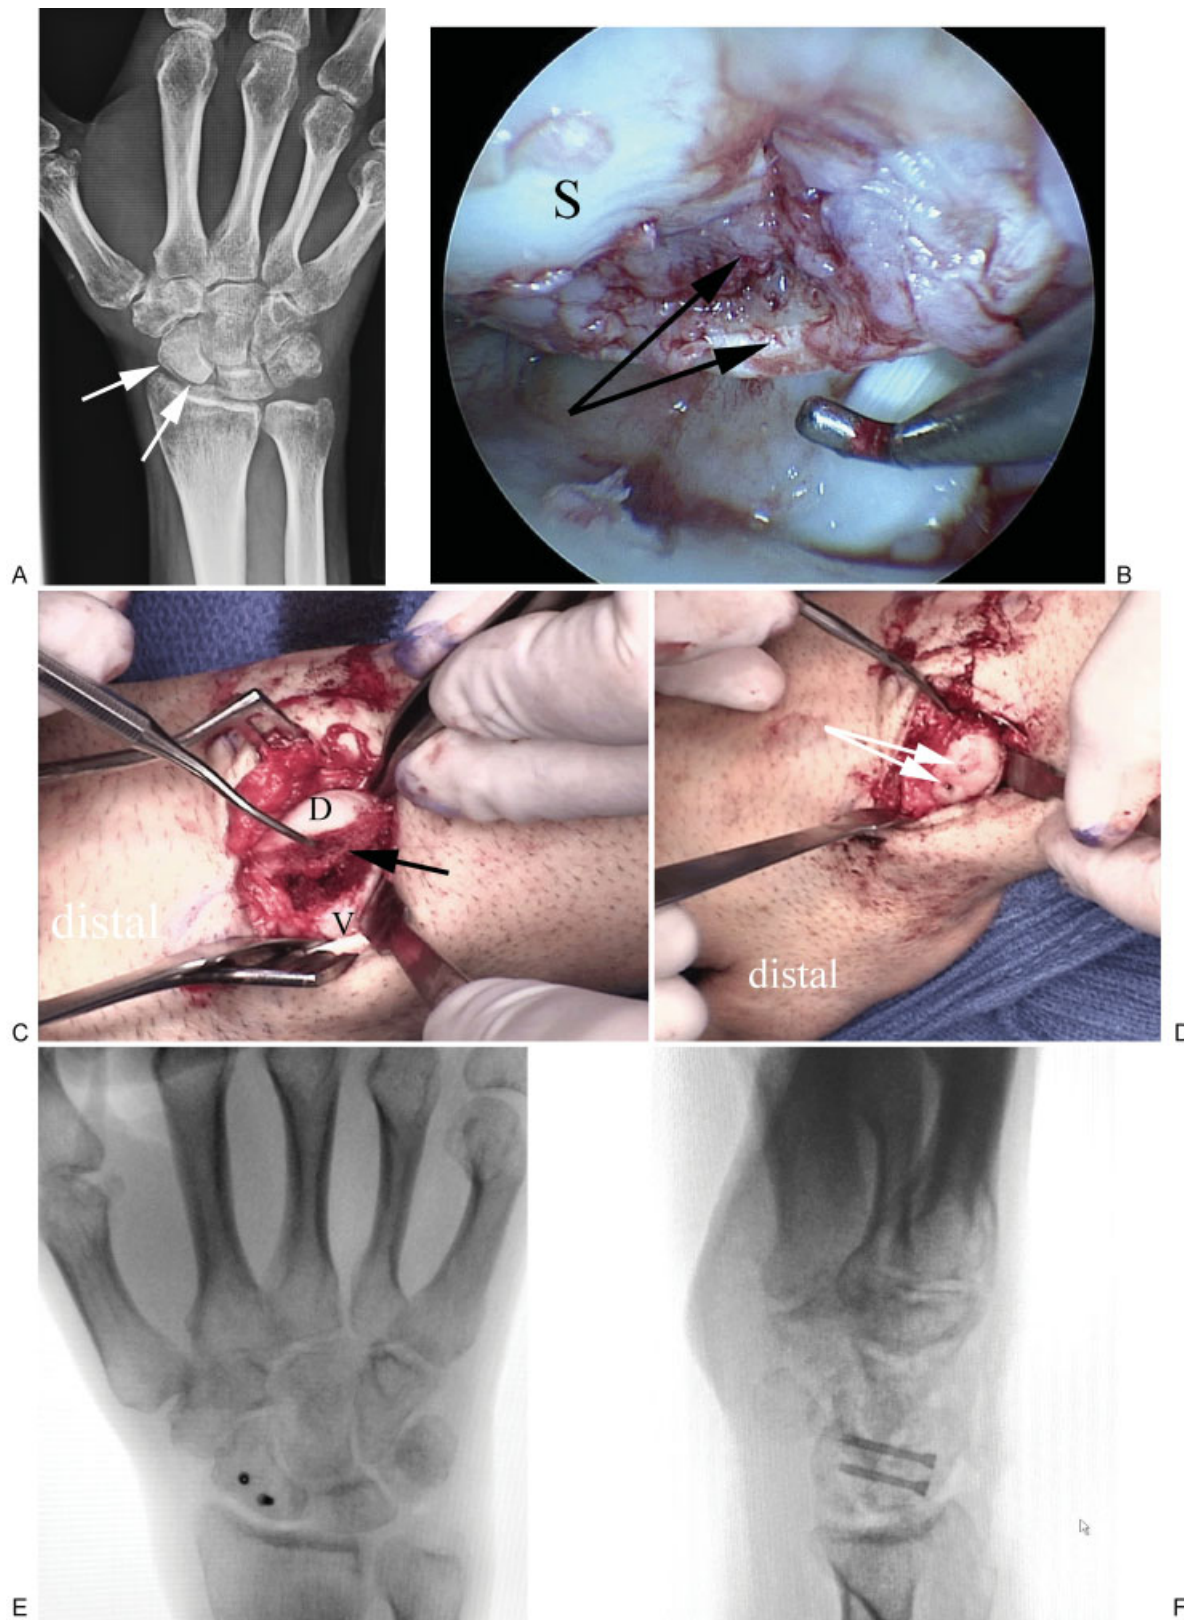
(A) Anteroposterior X-ray view of the right wrist demonstrating a double contour of the proximal pole of the scaphoid (arrows). (B) Arthroscopic view of the proximal scaphoid from the 3,4 portal. Arrows are highlighting the malunion site and the step-off of the proximal articular surface. (C) Intraoperative view of the dorsal aspect of the right wrist. The scaphoid fracture is being pried apart and opened like a clam shell, demonstrating the dorsal (D) and volar (V) fracture fragments. (D) Internal fixation of scaphoid with two horizontal headless screws (arrows). (E) Postoperative anteroposterior X-ray view of the right wrist demonstrating disappearance of the double contour of the proximal pole of the scaphoid. Note that the screws appear as small circles since they are passing from a dorsal to volar position. (F) Postoperative lateral X-ray view of the right wrist demonstrating the headless screws that are passing from a dorsal to volar position.
